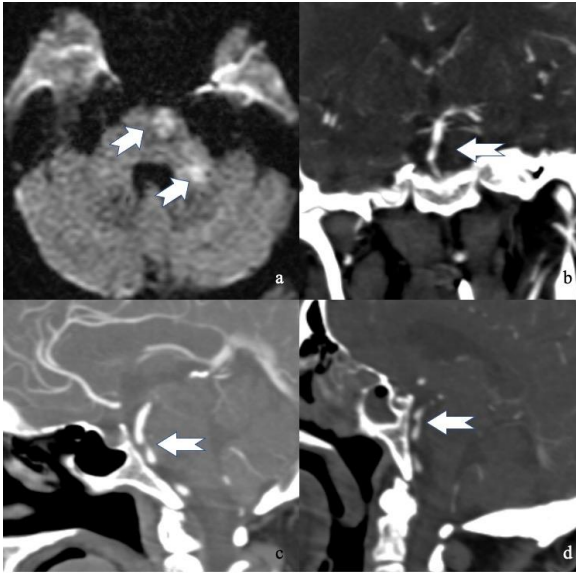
DWI at admission of Case 15, arrows show the acute ischemic lesions, b. CTA at admission at coronal plane, c. Sagittal plane CTA at admission, d. Sagittal plane CTA at follow up, arrows showing basilar artery stenosis.
